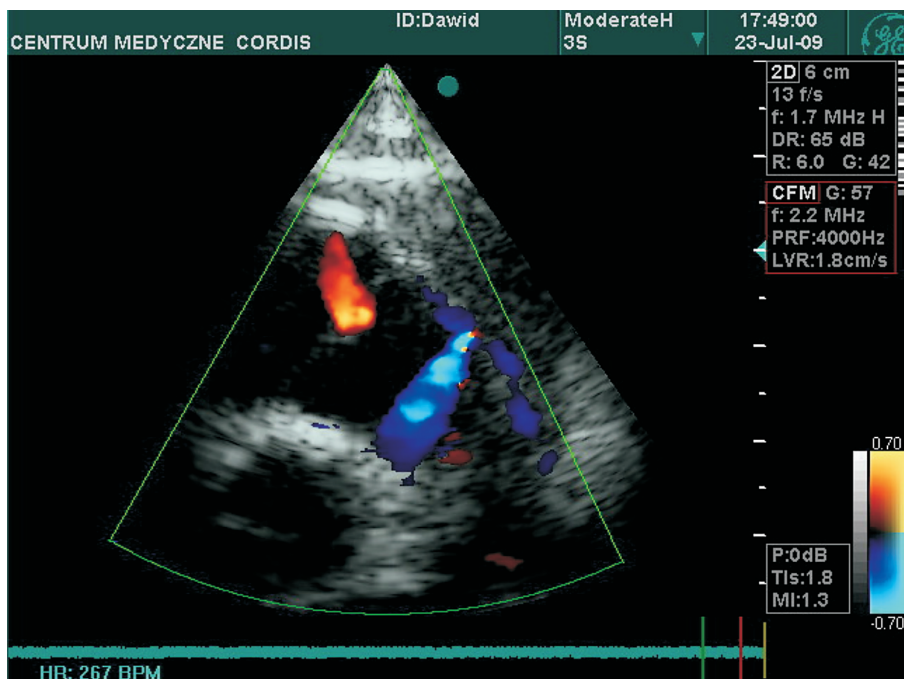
Echocardiography. Coronary fistula to pulmonary artery
